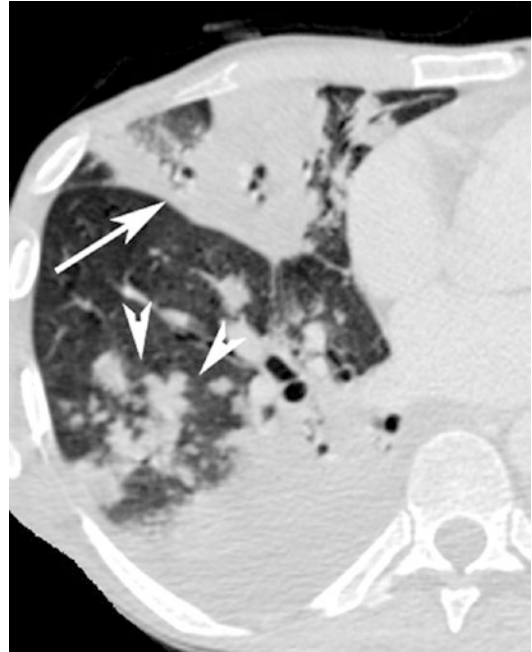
CT axial scan of the chest shows a peripheral wedge-shaped opacity (*arrow*) of the medium pulmonary lobe associated with multiple patchy opacities of the lower right pulmonary lobe
